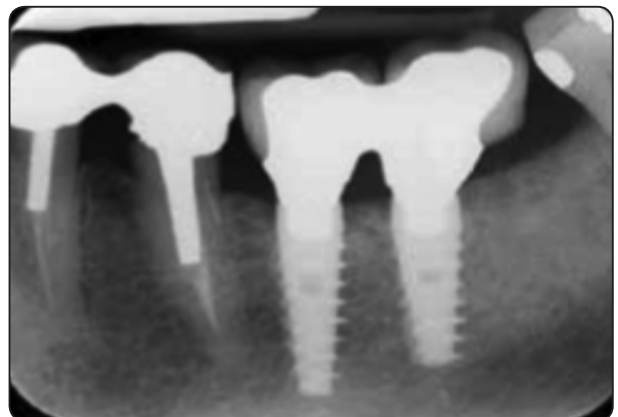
Periapical radiograph showing implants with final prosthesis four months postoperative.
